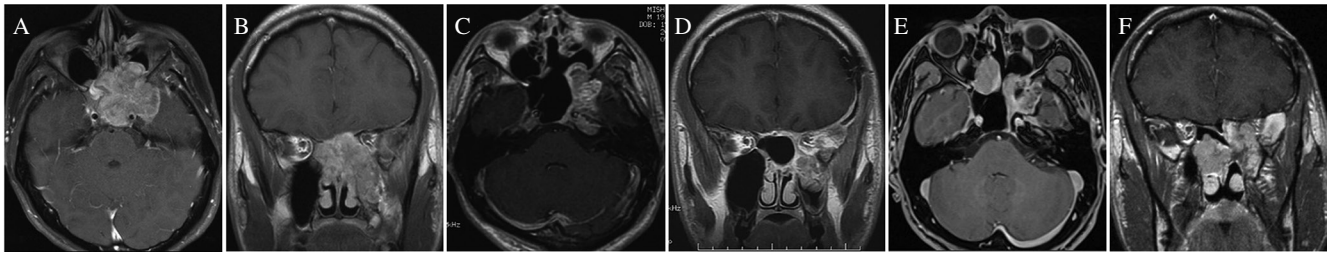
Preoperative (A, B) and postoperative (C, D) gadolinium-enhanced T1-weighted MRI at initial surgery, demonstrating left cavernous sinus tumors, which extended to the left mandibular sinus, sphenoid sinus, planum sphenoidale, orbit, temporal pole, and clivus, was subtotally removed. Recurrent tumors were found 30 months after initial surgery (E, F).
